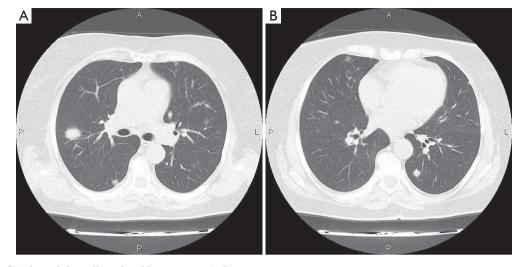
Chest CT shows bilaterally isolated lung tumors (A,B).
